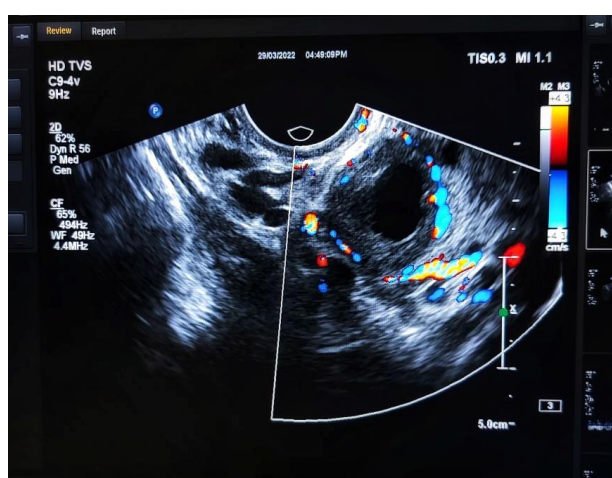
Classic “RING OF FIRE” appearance on colour Doppler of ectopic pregnancy.
